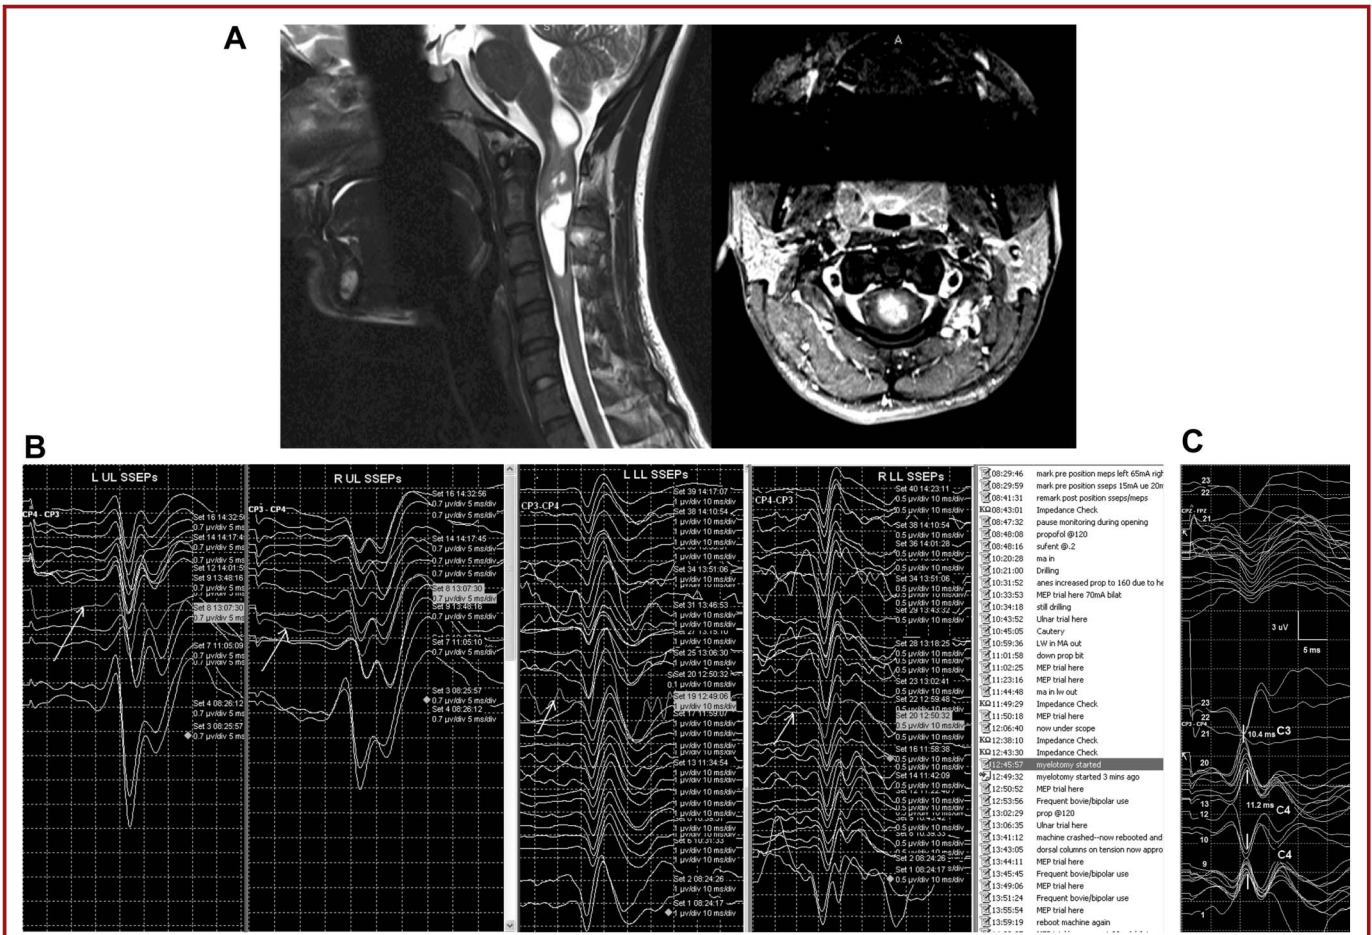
Intraoperative neurophysiologic testing in patient 2 during resection of cervical ependymoma. A, MRI sagittal and axial images showing hyperintense cervical lesion at C1–C4. B, continuous upper limb (ulnar nerves) and lower limb (posterior tibial nerves) SSEP monitoring. No significant changes from baseline are seen during and after myelotomy and throughout the resection. In each window, the first 2 traces (bottom of the stack) show preposition baseline SSEPs. As a direct result of the effect of anesthetics during the opening time, all SSEPs recorded after the opening have overall lower amplitudes than the preposition baselines. The arrows point to the first SSEP recordings (highlighted) after the beginning of myelotomy (see also notes in the recording’s log). C, DCM in the same patient. Channel CP3–CP4: Stimulation from right to left at C4 level triggers negative deflections with absolute latency of 11.2 ms (trials 1 through 9) due to depolarization of the right gracilis tract, followed by positive deflections with same latencies (trials 10 through 12) triggered by stimulation of the left gracilis tract. The phase reversal between trials 9 and 10 points toward the location of the MR. The midline is crossed once again (phase reversal between trials 12 and 13) from left to right (trial 13 shows a negative deflection triggered by stimulation of the right gracilis tract). Next, the surgeon performs successive stimulation of the right DC, tracking its trajectory proximally, from C4 toward C3 level. Notice the progressive shortening of the absolute latencies from trial 13 (11.2 ms) to trial 20 (10.4 ms). Once again, the stimulation is performed from right to left, this time at the C3 level. Stimulation of the MR results in a relatively isoelectric line (trial 21) recorded in both CP3–CP4 as well as CPz–Fz channels. Stimulation of the left gracilis tract results in positive deflections (trials 22, 23). Channel CPz–Fz: Stimulation of either right or left gracilis tracts results in positive deflections. A small arrow indicates the start of the stimulus. DC, dorsal column; MR, median raphe; SSEP, somatosensory evoked potential.
